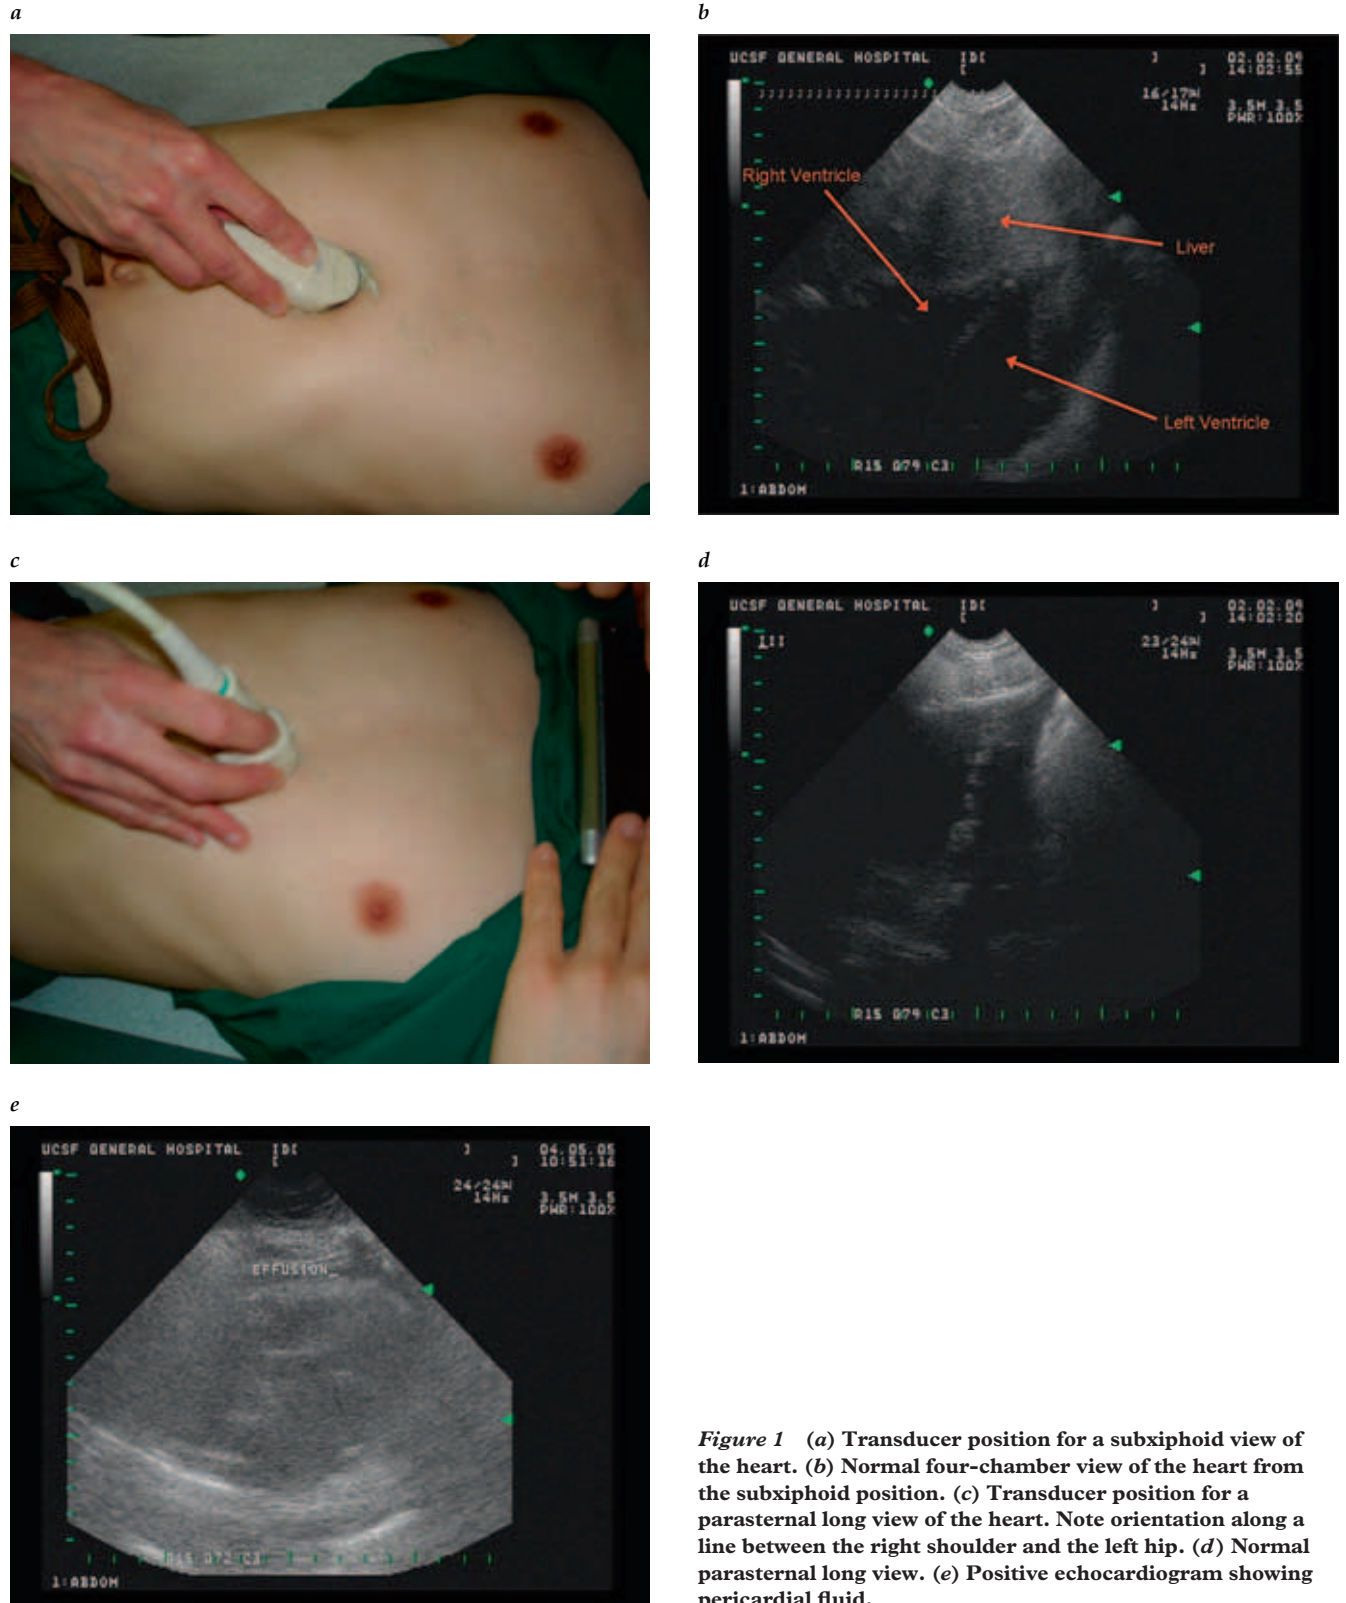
(a) Transducer position for a subxiphoid view of the heart. (b) Normal four-chamber view of the heart from the subxiphoid position. (c) Transducer position for a parasternal long view of the heart. Note orientation along a line between the right shoulder and the left hip. (d) Normal parasternal long view. (e) Positive echocardiogram showing pericardial fluid.
